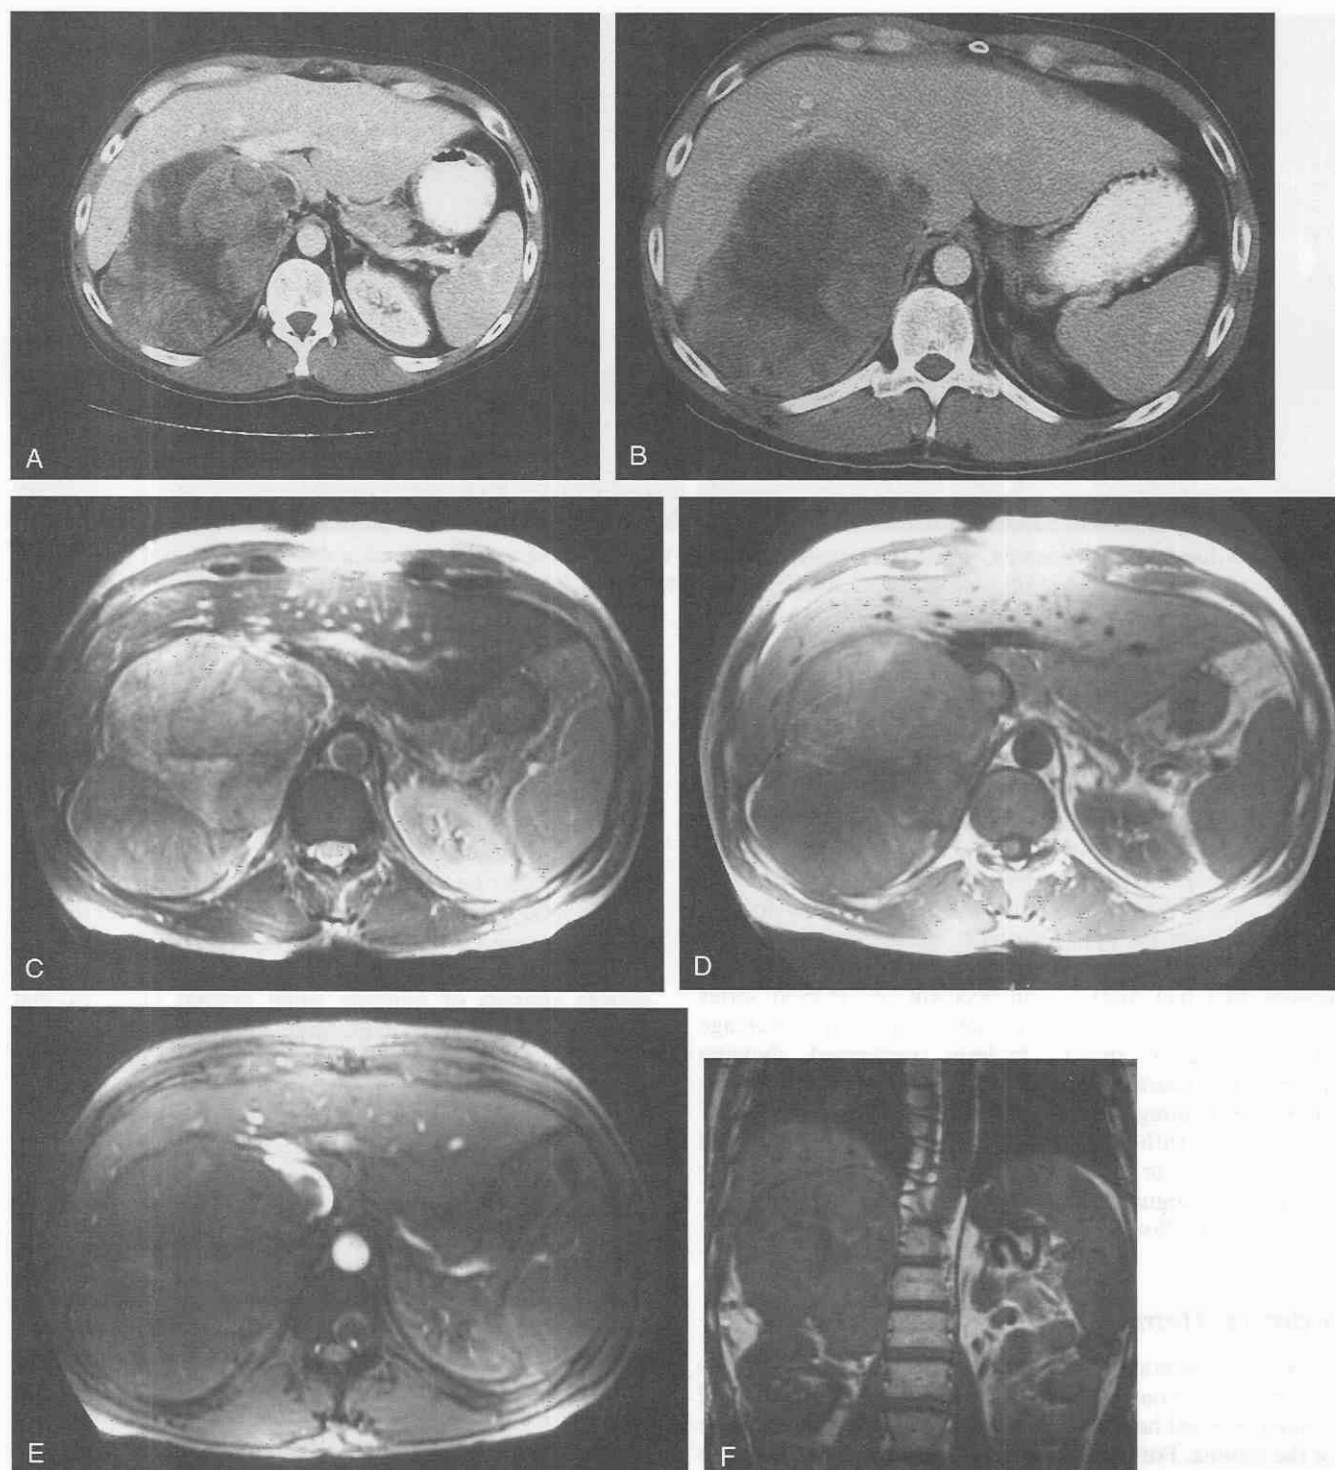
Adrenal cortical carcinoma. *A* and *B*, Contrast-enhanced CT scans of the abdomen demonstrate a large heterogeneous right adrenal mass invading the inferior vena cava. *C-F*, MR images demonstrate a large right adrenal cortical carcinoma with invasion of the inferior vena cava.
